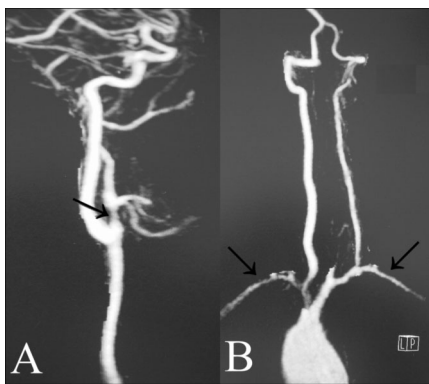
Computed Tomography Angiography of the Neck. (A) Bifurcation of the right common carotid artery showing area of stenosis (arrow) in the proximal external carotid artery. (B) Narrowing and contour abnormalities (arrows) in both subclavian arteries.
